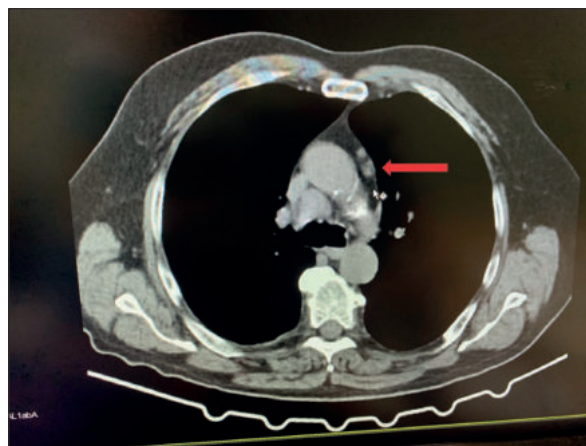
Spiral CT scan of the mediastinum and lungs, 3D reconstructions.
